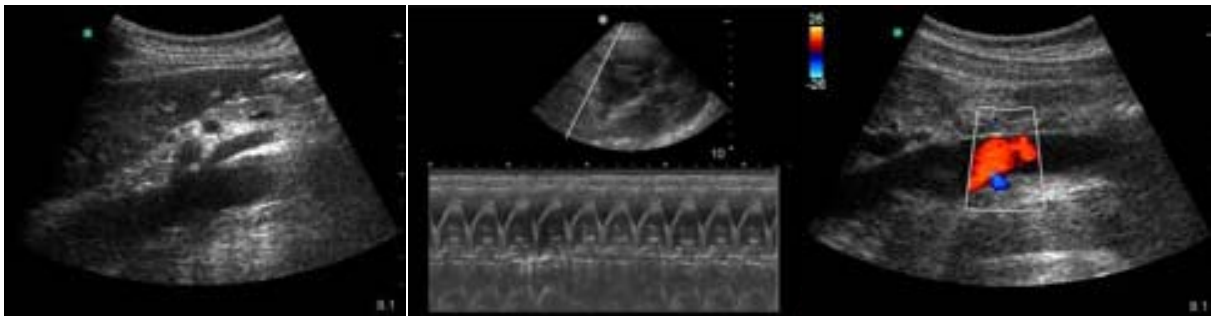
From left to right, (a) Sample of B-Mode image, (b) M-Mode combined with B-Mode image, (c) Sample of Doppler image [<http://www.sonoguide.com/physics.html>].
